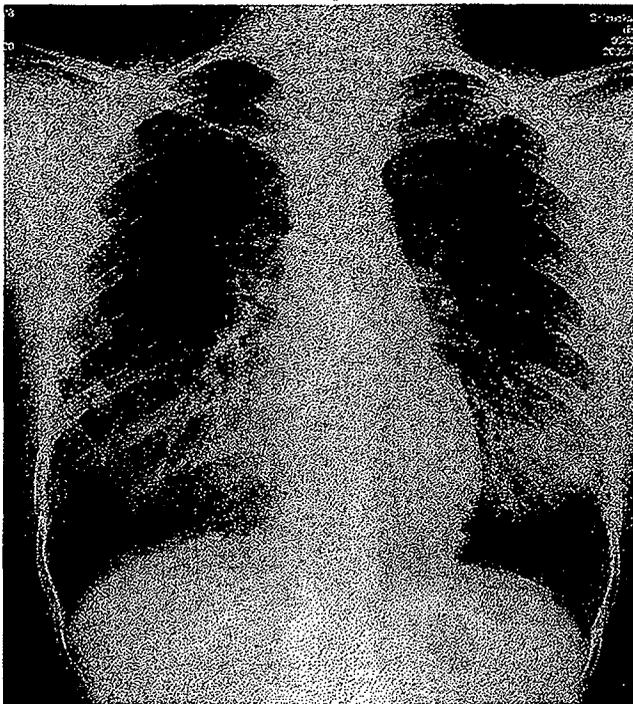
Admission chest radiograph shows bilateral hyperinflation and reticulonodular opacities that are predominantly hilar in distribution.
